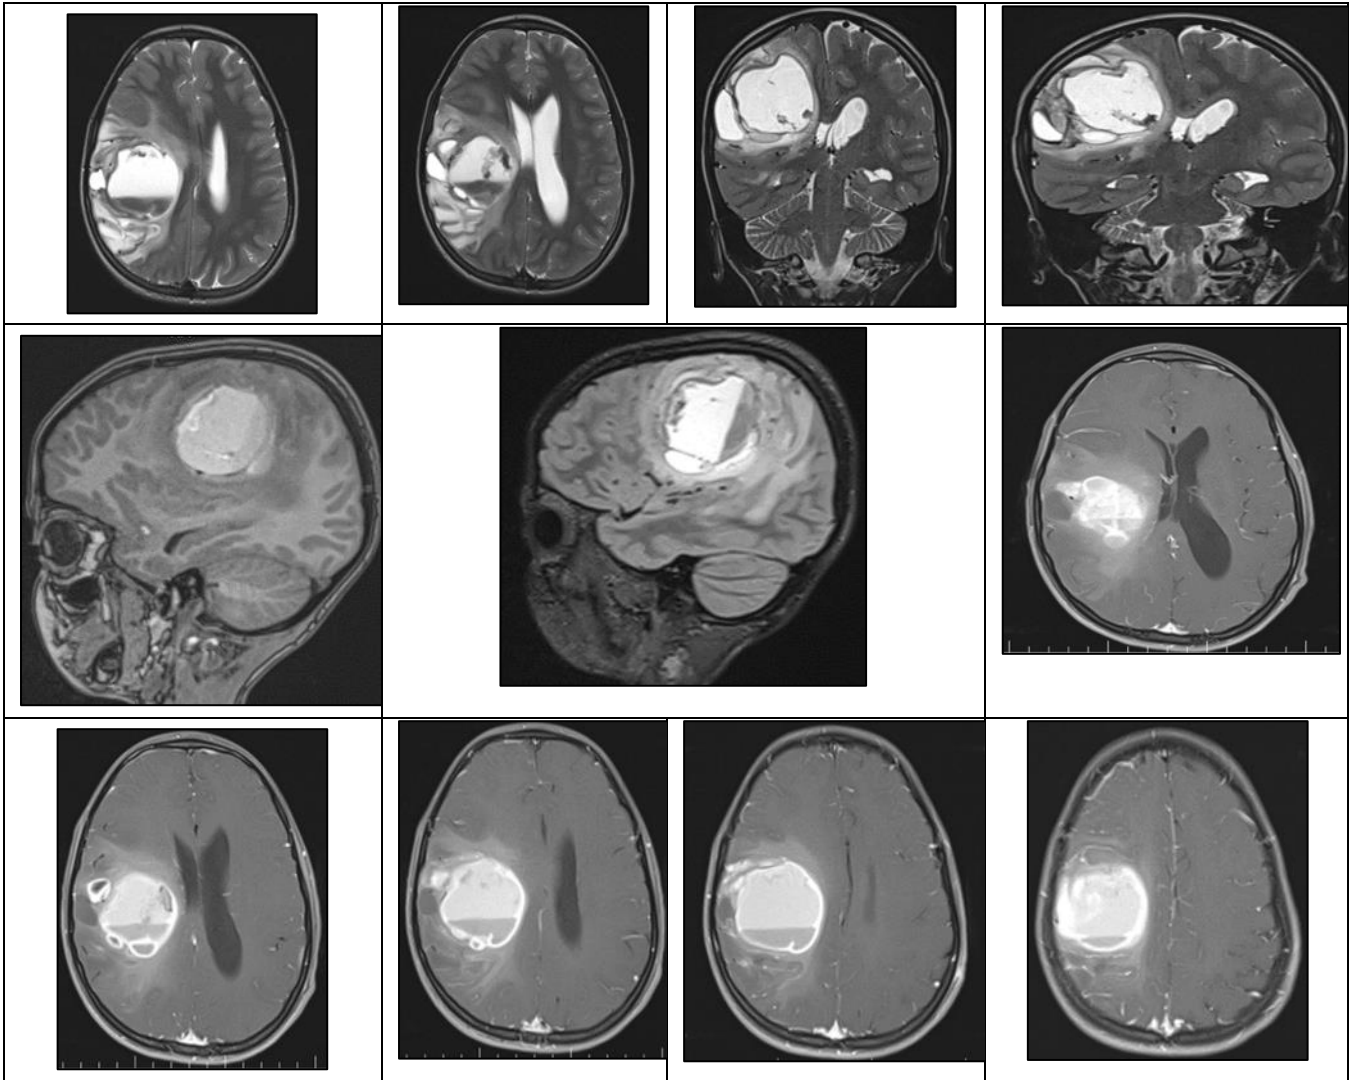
Brain MRI demonstrating a right frontal superficial leptocortical supratentorial mass, composed of a solid enhancing component and a multiloculated cystic portion. The lesion exhibits marked perilesional infiltration, with the solid component, cyst wall, and internal septations showing intermediate signal intensity on T1- and T2-weighted images, associated intense heterogeneous gadolinium enhancement. An intralesional hemorrhagic component with a fluid–fluid level is also identified
